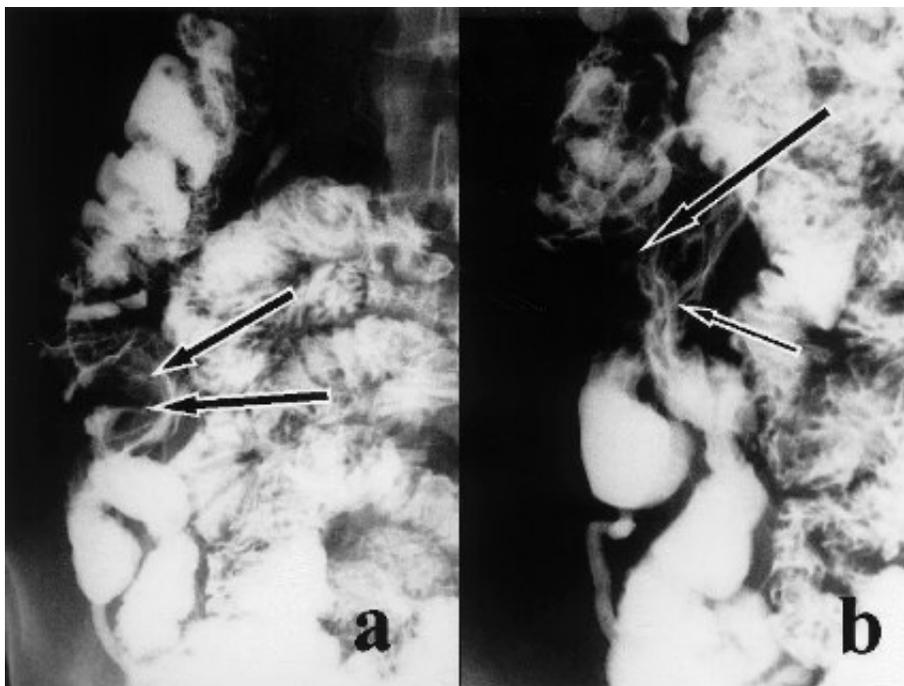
a e b) Abdominal barium x-rays (8/7/1998). Terminal tract of the ileus reveals a slight mucous lining. The first tract of the ascending colon shows an apparently "extrinsic" filling defect riverberating on the terminal ileum. Caecum and appendix are full of barium. This latter aspect suggests an obstacle for contrast means to pass from caecum to ascending colon. The mucus lining lacks infiltrating dismorphism.
